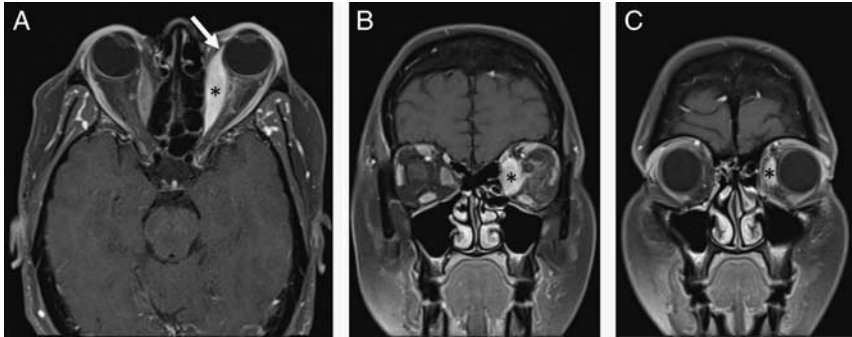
45-year-old woman presented with left eye pain and diplopia for 3 weeks and subsequently underwent biopsy of the medial rectus demonstrating pseudotumor. Axial (A) and coronal (B, C) T1-weighted postcontrast fat-saturated magnetic resonance imaging demonstrates abnormal thickening and enhancement of the left medial rectus (black asterisks) with involvement of the myotendinous junction (white arrow) and stranding within the intraconal fat. Involvement of the myotendinous junction can be subtle as in this case and comparison with the normal right side is helpful for identification.
